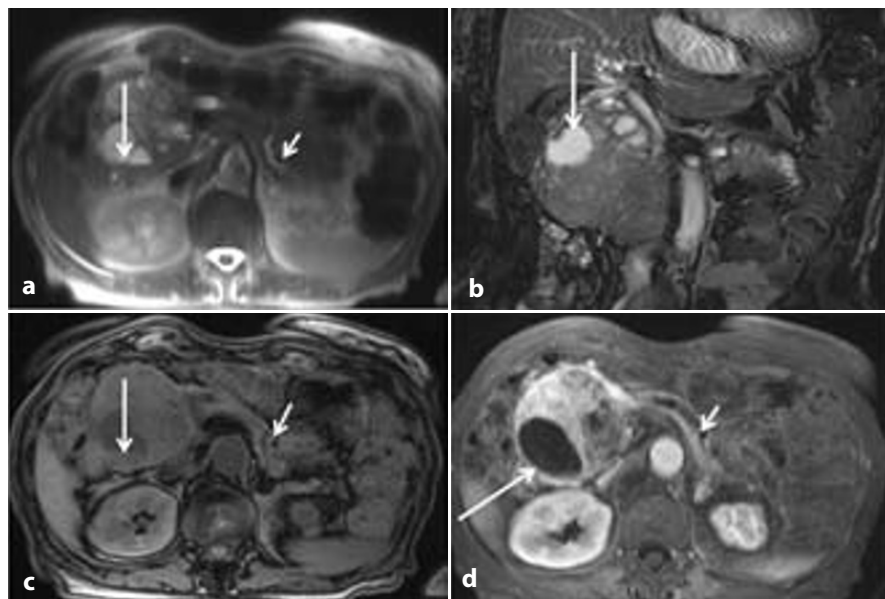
Typical MRI findings of large NF-PanNEN/Cs. Pre-contrast examination shows a large tumor of the pancreatic head with upstream dilatation of the main pancreatic duct (*short arrow*). The lesion is markedly inhomogeneous on axial (a) and coronal (b) T2-weighted images and on the axial T1-weighted image, presenting intralesional necrosis and cystic changes with a fluid-fluid level (*long arrow*). After gadolinium administration (d), tumor inhomogeneity due to cystic change is confirmed (*long arrow*)
